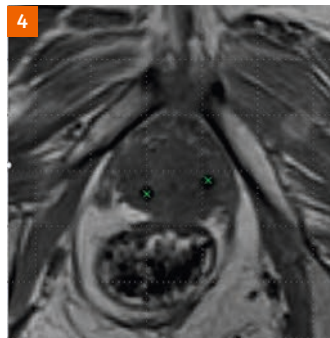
T1-weighted prostate 3T MRI from Karolinska with Gold Anchor 0.28 mm x 20 mm.
